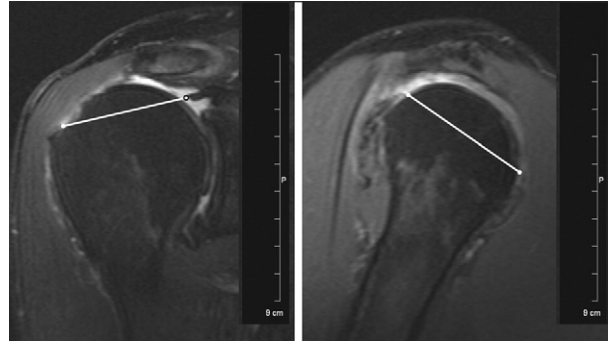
Clinical example of a type 3, massive contracted tear on MRI with maximum coronal length (left) and maximal sagittal length (right) both greater than 2 cm.
